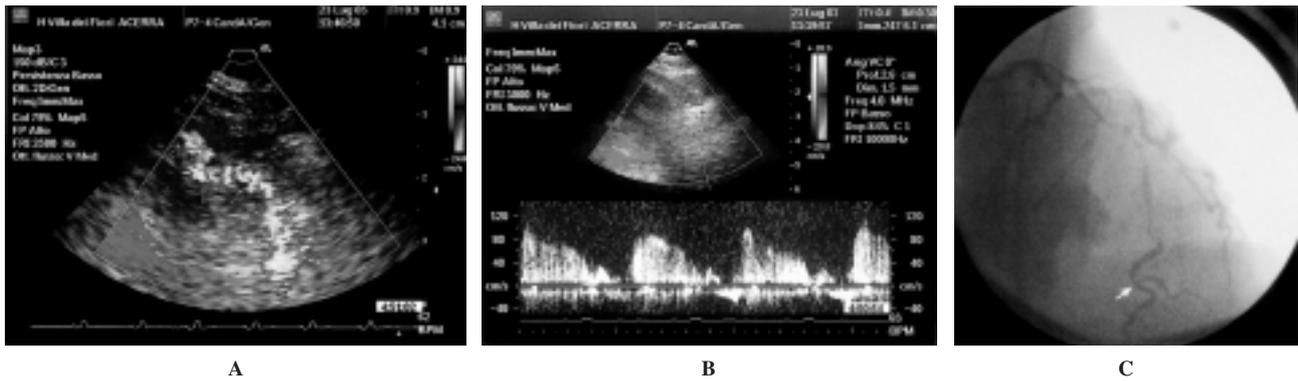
Kinking of the distal left anterior descending coronary artery with intermediate anatomic stenosis. A: presence of aliasing at color Doppler; B: increased diastolic velocity, mild spectral broadening, absence of negative frequencies at pulsed Doppler; C: coronary angiography showing the presence of kinkings along the entire mid-distal left anterior descending coronary artery segment.
